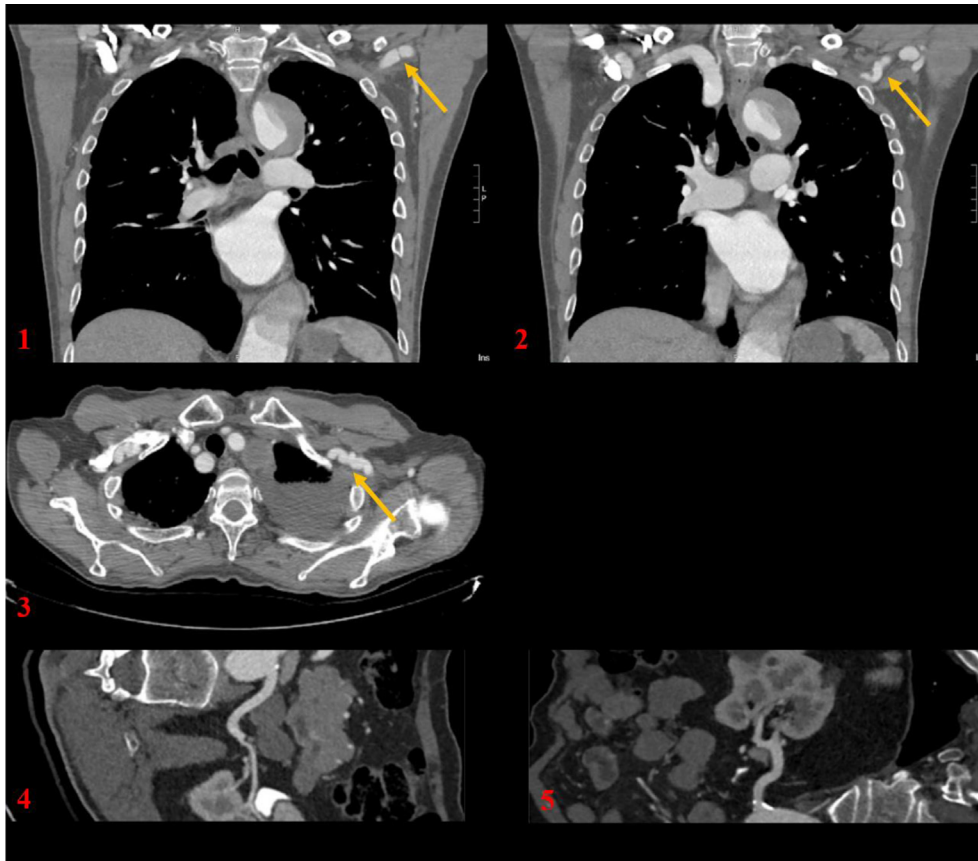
Selected computed tomography angiographic images. *Yellow arrows* indicate webbing, tortuosity, and beading consistent with fibromuscular dysplasia (FMD). Also visible is patient's thoracic aortic aneurysm resulting from his acute type B dissection. 4,5, Contour mapping of right and left renal arteries, respectively, with no evidence of FMD within the renal arteries identified.
